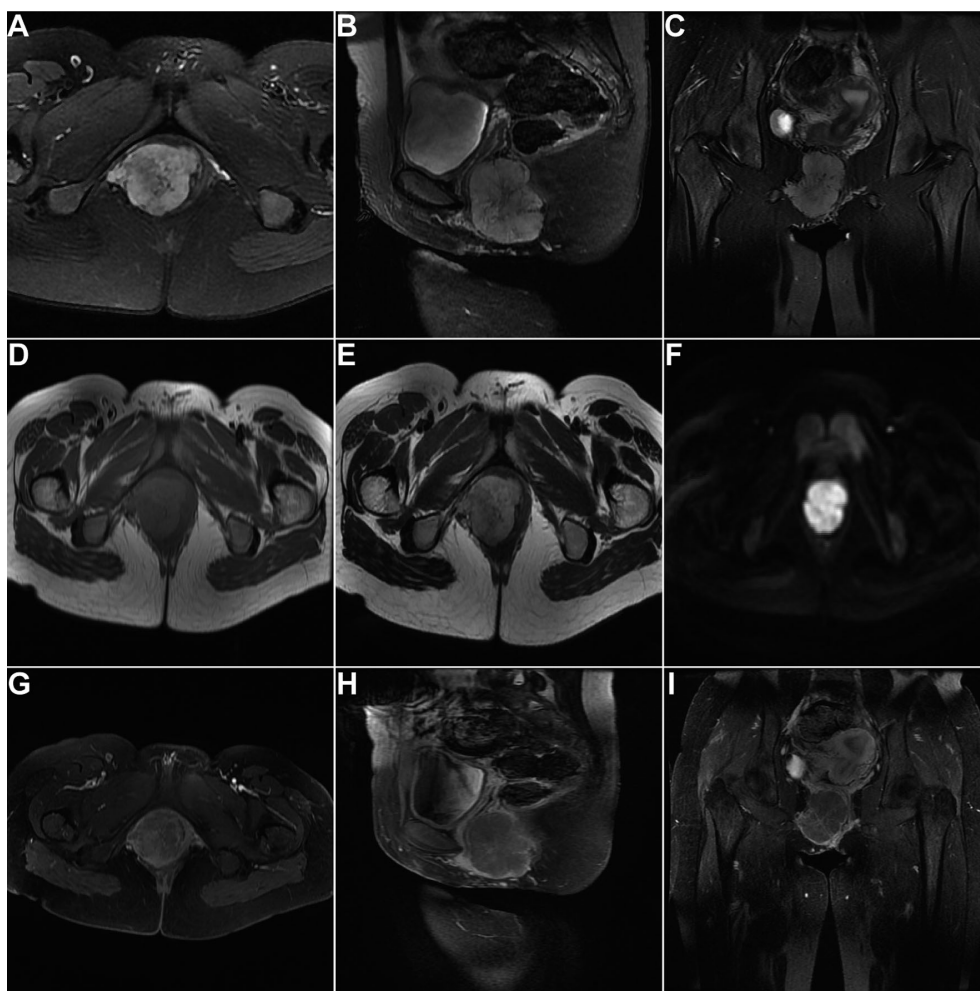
The axial (A), sagittal (B), and coronary (C) FS-T2 weighted images displayed an irregular lump with heterogeneous hyperintensity in the lower pole of the right labia majora, which involved the anal sphincter. The in-phase (D) and out-phase (E) T1 weighted images showed there was no obvious signal decreasing. The mass revealed obvious inhomogeneous hyperintensity on diffusion weighted image (DWI) (F). The axial (G), sagittal (H), and coronary (I) contrast enhanced T1 weighted images showed that the mass was significantly enhanced.
